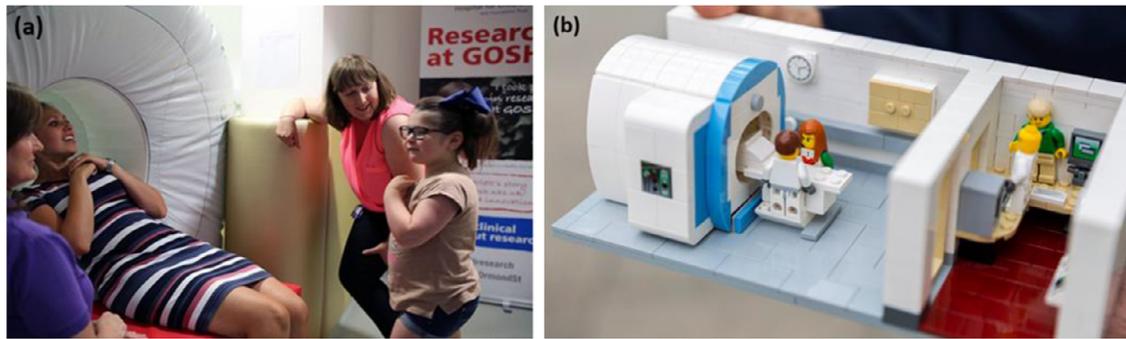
Images depicting alternative play therapy methods: (a) a child being shown an inflatable MRI scanner to prepare for a scan, (b) a lego-scale version of an MRI scanner and control room [Images shared with permission, GOSH].
